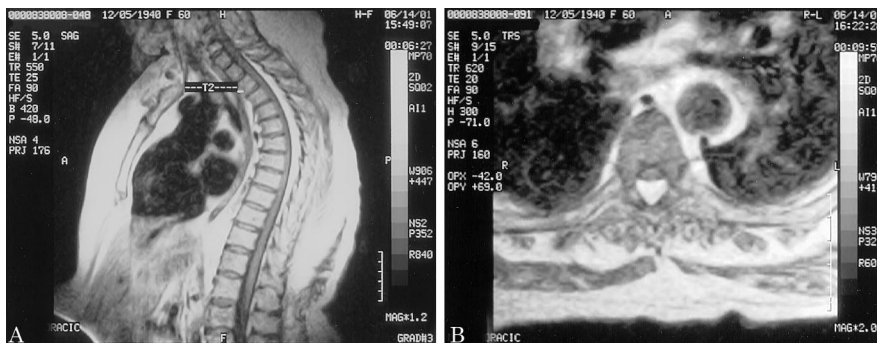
MRI with gadolinium of the cervico-thoracic-lumbar spine. T1-weighted sagittal (A) and axial (B) images demonstrate the presence of epidural fat from T1 to T9 and thecal sac compression.
